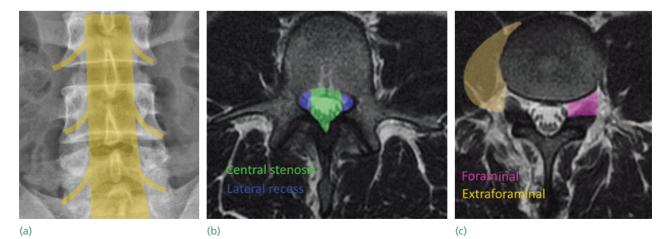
Spinal stenosis – anatomical regions (a) X-ray relationships of the dural sac and exiting nerve roots – note how the roots closely exit under the pedicles; (b) central spinal canal and lateral recess; (c) the foraminal region and extraforaminal region.
